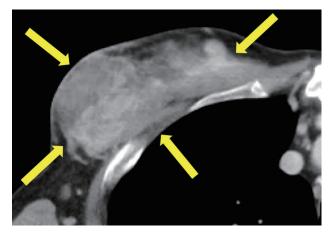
Enhanced computed tomography. A heterogeneous increase in density was seen in the right breast (yellow arrow). A tumor structure in the right breast infiltrating the chest wall was suspected. The border with the muscle was unclear.
